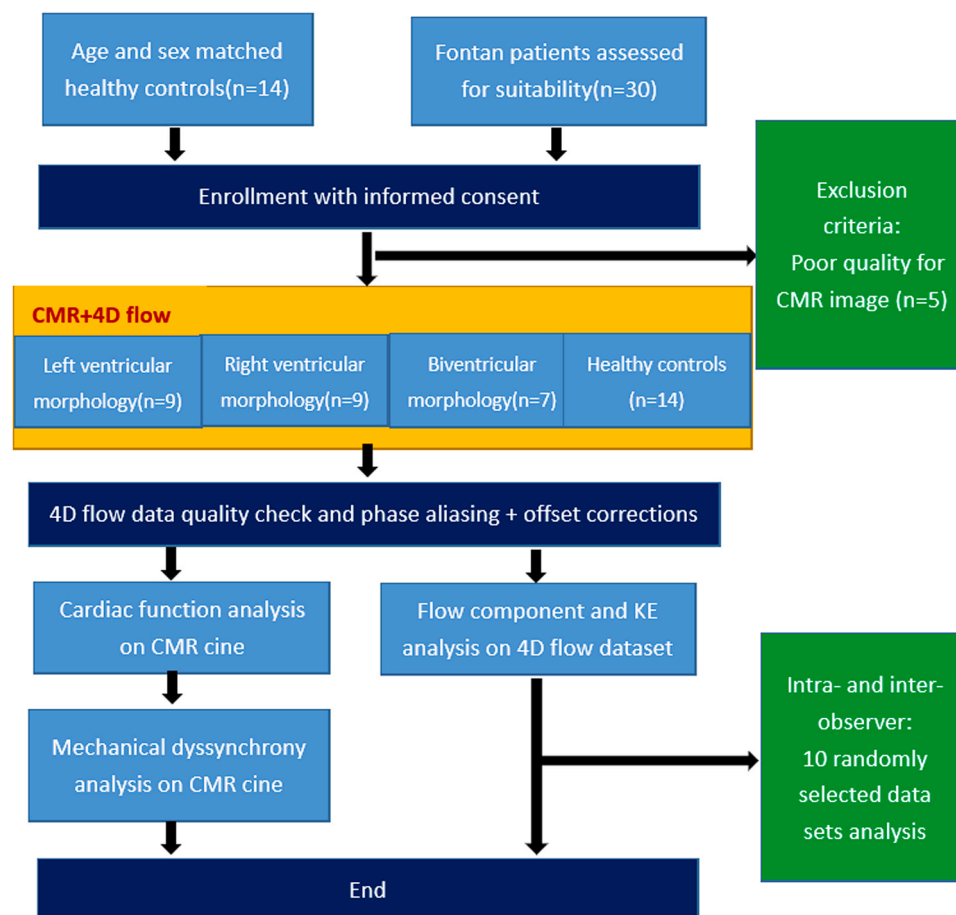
Study design. 4D = four-dimensional; CMR = cardiovascular magnetic resonance imaging; KE = kinetic energy; CMR =cardiovascular magnetic resonance.
